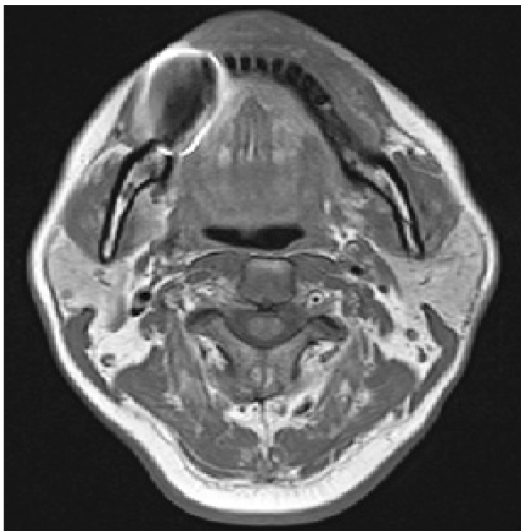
Preoperative magnetic resonance imaging axial view.
